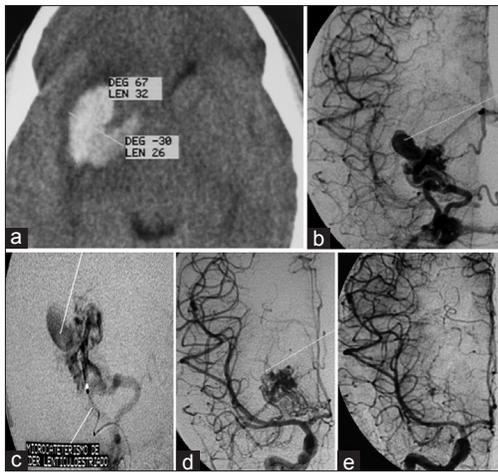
Preradiosurgical embolization of an intranidal aneurysm. (a) Computed tomography scan showing a basal ganglia hematoma. (b) Digital subtraction angiogram (DSA) of the right internal carotid artery (ICA) showing an intranidal aneurysm, identified as the bleeding source. (c) A lateral lenticulostriate artery was catheterized to embolize the aneurysm with n-butyl cyanoacrylate. (d) DSA after embolization shows disappearance of aneurysm. The residual arteriovenous malformation (AVM) was then treated with stereotactic radiosurgery (SRS). (e) A DSA of the right ICA performed 28 months after SRS shows complete cure of the AVM
